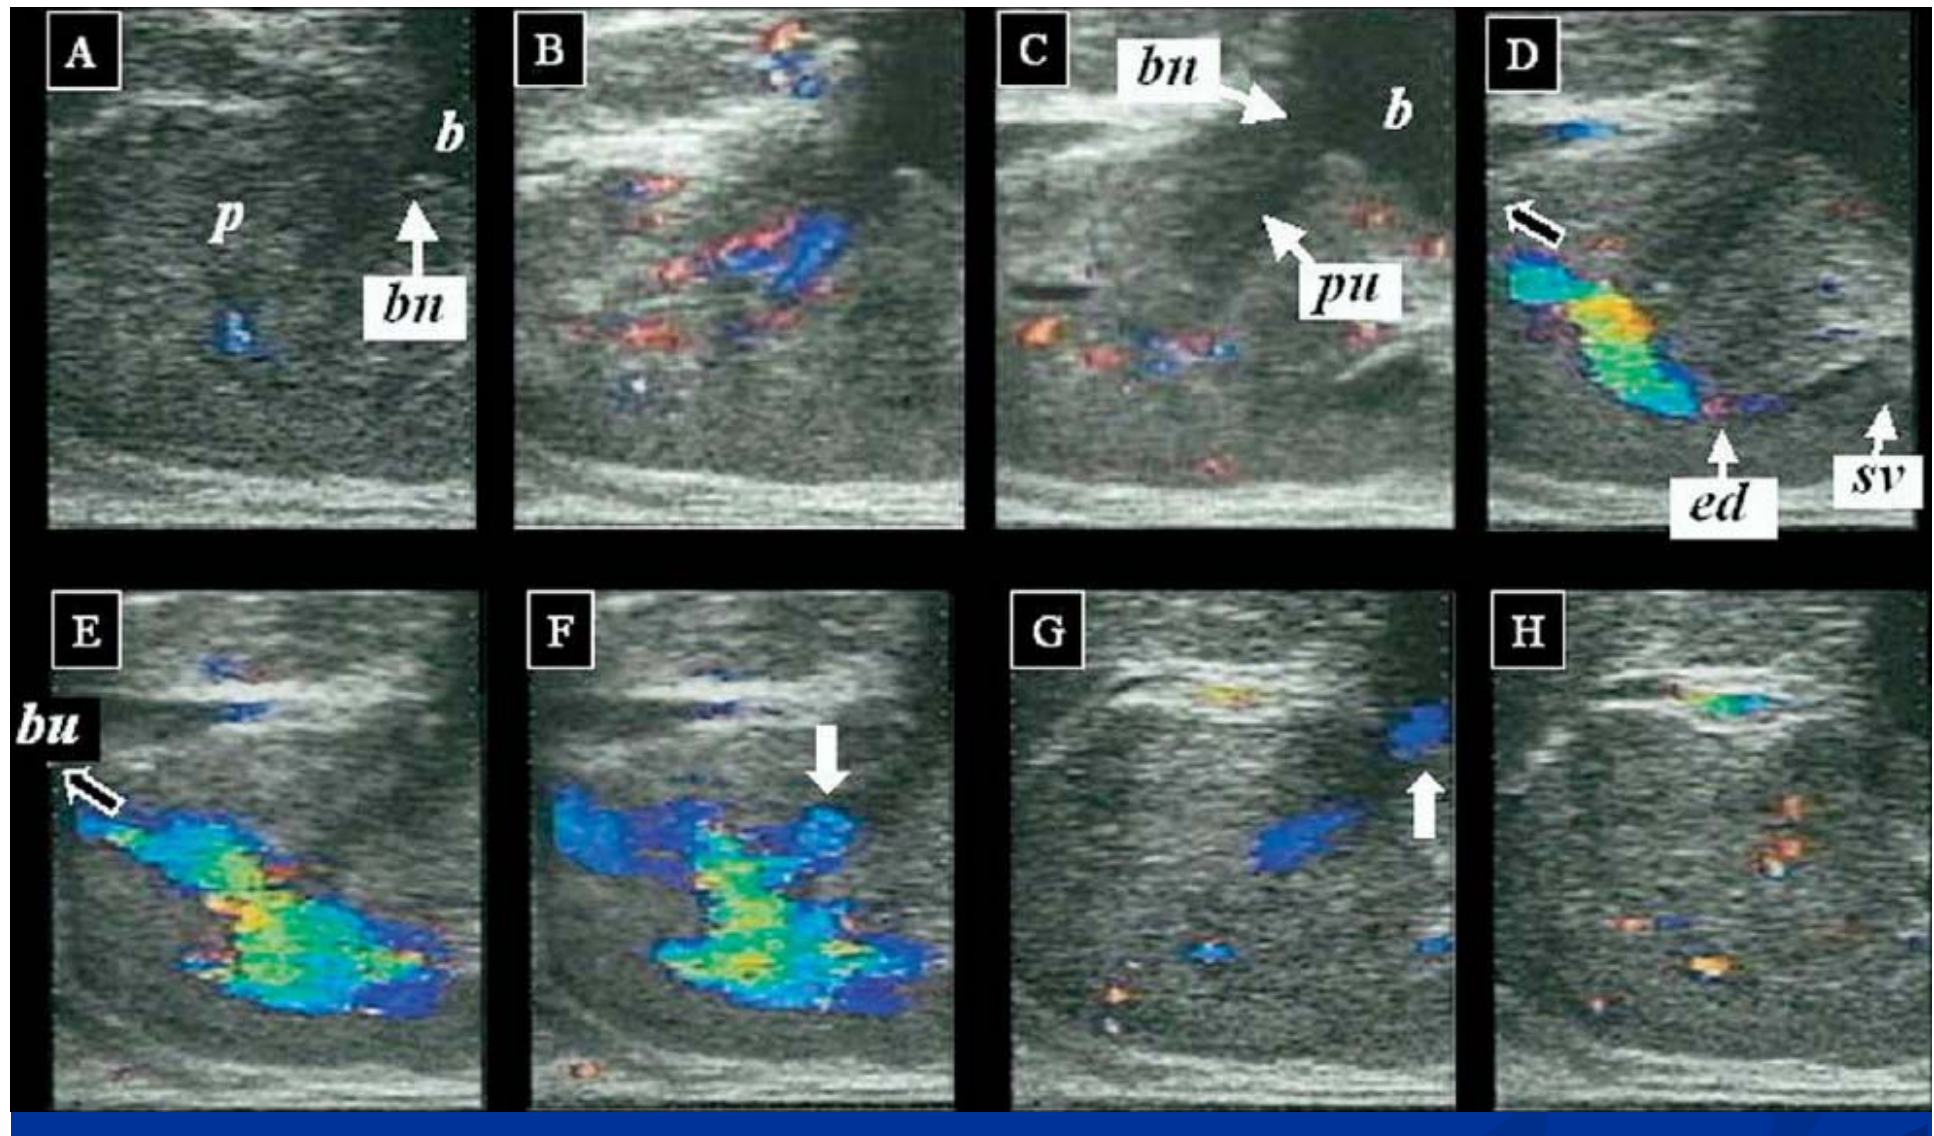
Color Doppler ultrasound images of ejaculation in healthy male: (A) Prostate (*p*), bladder neck (*bn*), and bladder (*b*). (B) Blood flows in prostate and prostatic venous plexus increase during penile stimulation. (C) Distension of prostatic urethra (*pu*) and flattening of bladder neck (*bn*) with contraction of prostate. (D,E) Ejaculatory stream (black arrow) from seminal vesicles (*sv*) spurting toward bulbous urethra (*bu*) through ejaculatory duct (*ed*). (F) Flow toward supramontanal portion (white arrow) without any flow into bladder. (G) Bladder neck opens after expulsion, and semen remaining in prostatic urethra flows into bladder (white arrow). (H) Prostatic urethra and bladder neck return to normal.
